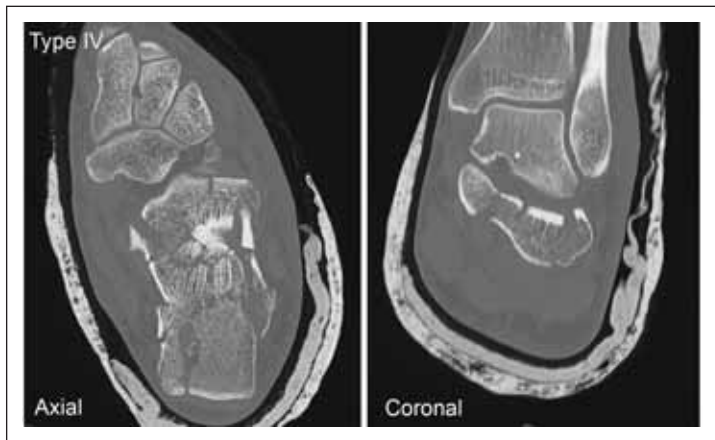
Axial and coronal CT scan images of Sanders Type IV fracture with three fracture lines.
